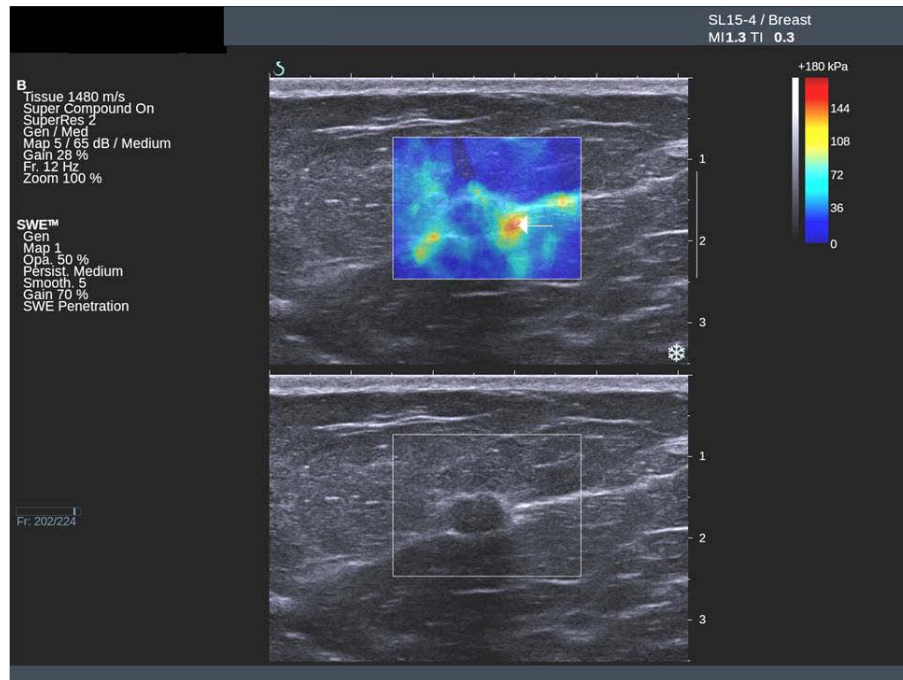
Ultrasound and elastography images of an invasive breast cancer. Ultrasound image showing a normal area with greyscale features but suspicious peri-tumoural stiffness on the elastography image (arrow). [46]
